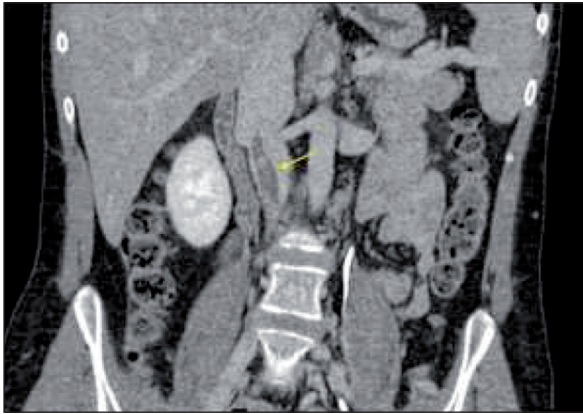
Coronal reformatted contrast enhanced CT image shows hypodense thrombus in inferior vena cava.
